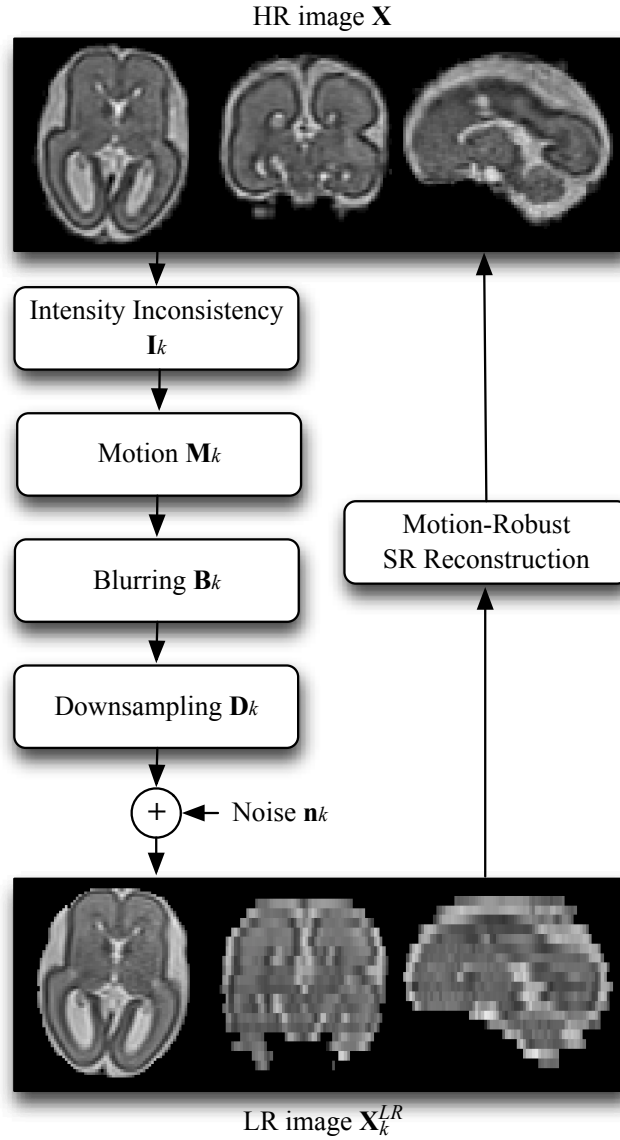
The observation model of a real MR imaging system relating the low-resolution (LR) image \mathbf{X}_k^{LR} (observed images) to an high-resolution (HR) image \mathbf{X} . The SR reconstruction step corresponds to the inverse problem, i.e., finding \mathbf{X} given the observations \mathbf{X}_k^{LR} .
